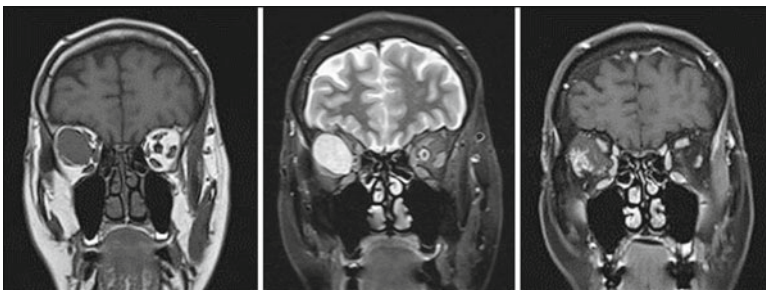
MRI of a patient with an orbital hemangioma. *Left:* $T1$ -weighted coronal section. *Middle:* $T2$ -weighted coronal section with fat suppression. *Right:* $T1$ -weighted
